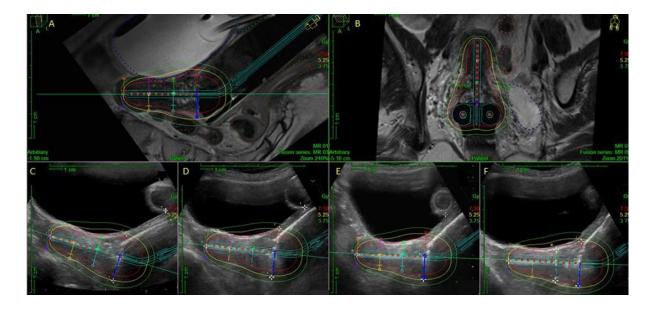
Treatment plan evaluated on ultrasound and MRI
